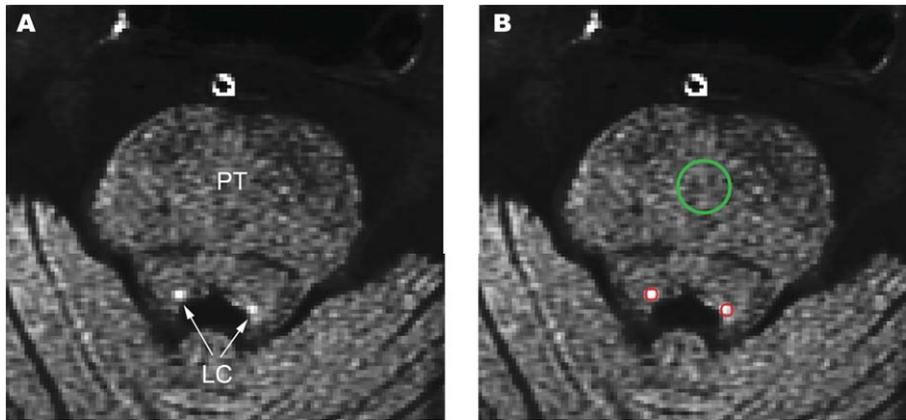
The anatomical location of the locus coeruleus (LC) and pontine tegmentum (PT). An NM-MRI slice of a healthy control (A) and the corresponding selected regions of interest (ROIs) of LC and PT (B).
